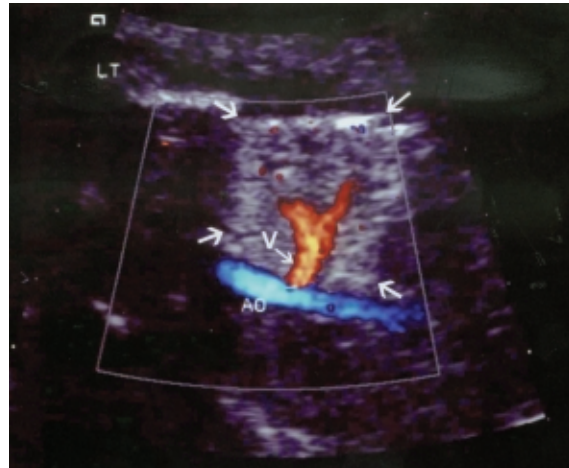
Coronal colour Doppler ultrasonogram of the foetal thorax (case 4) shows a systemic vessel (V) leading to the echogenic lung mass (arrows). (AO: aorta)
